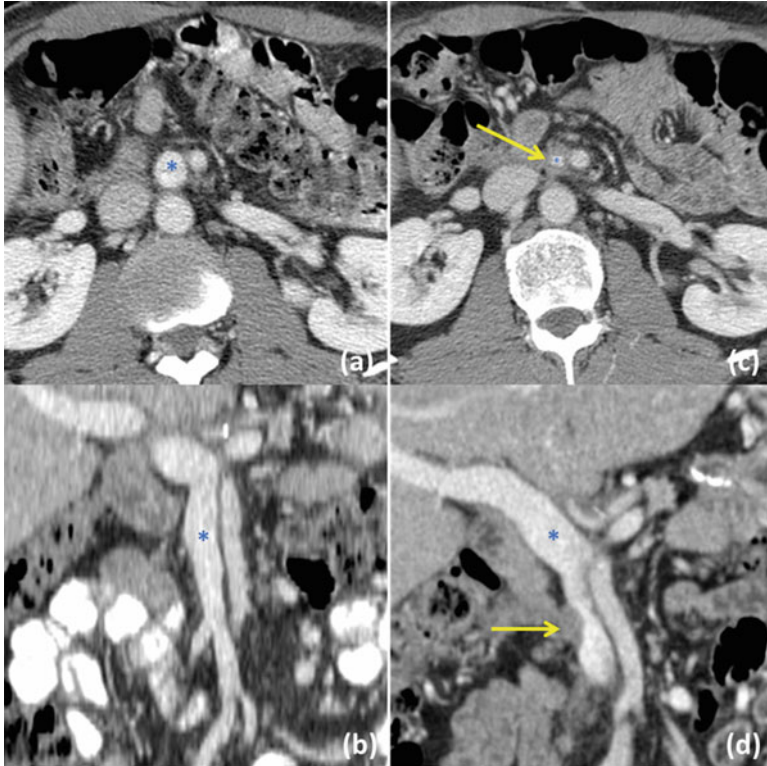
Local tumor recurrence. Immediate postoperative (a,b) and 1-year follow-up (c,d) CT portal-venous phase images in the axial and coronal planes. Note the normal diameter of the SMV (blue *) and the normal tissues surrounding the SMV on immediate postoperative exam. 1-year follow-up exam after surgery demonstrates locoregional tumor recurrence encasing the SMV (blue *) for 360° (yellow arrow)
